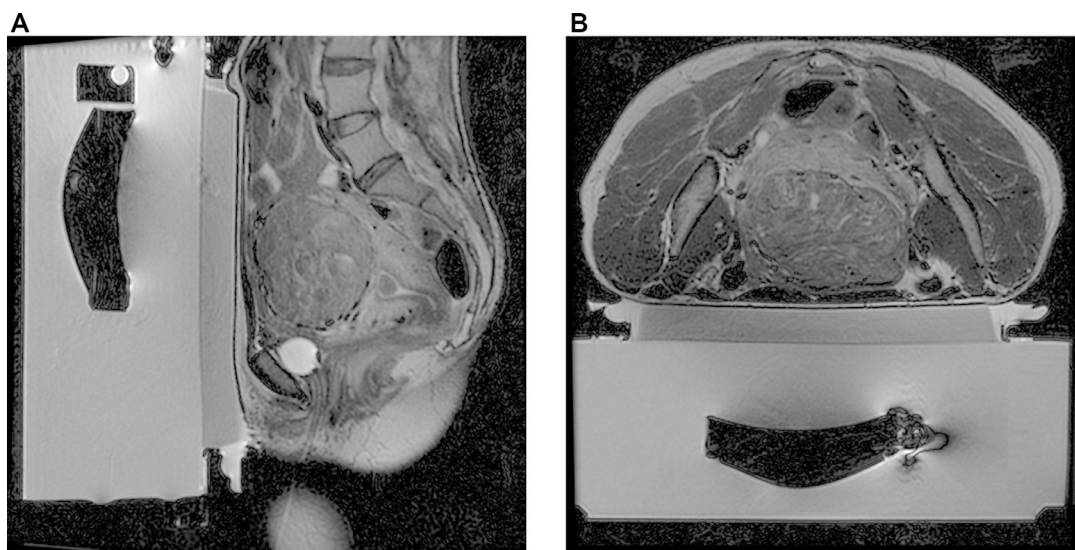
Sagittal (A) and Axial (B) T2-weighted MRI images acquired just before a MRgFUS procedure for the ablation of a UF with a diameter of 8cm. The patient is positioned prone on the MRI table, with the abdomen in a water bath of deionized degassed water, in contact with an acoustic coupling gel pad located above the ultrasound transducer; a Foley catheter has been previously positioned. These images are taken at the beginning of the treatment planning, in order to verify the correct patient positioning and the absence of air bubble trapped between the skin plane and the table.
